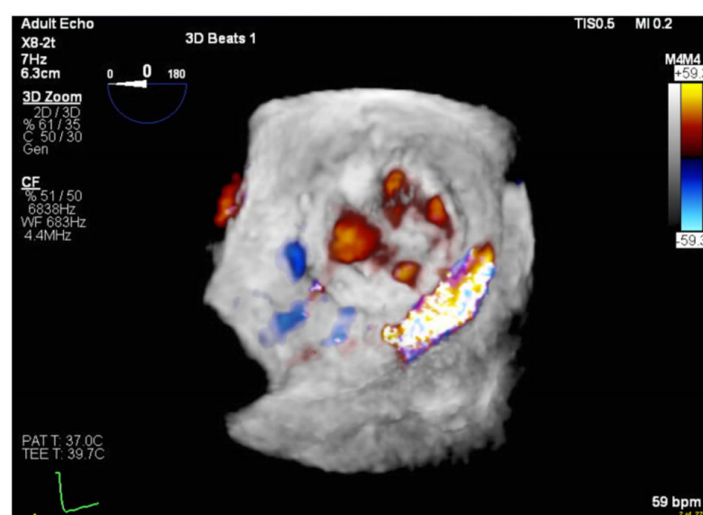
Transesophageal 3D-color assessment of a paravalvular leak
